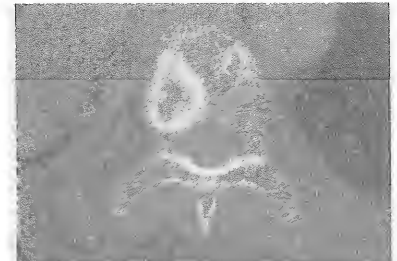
CT scan showing two metastatic deposits in a vertebra.
